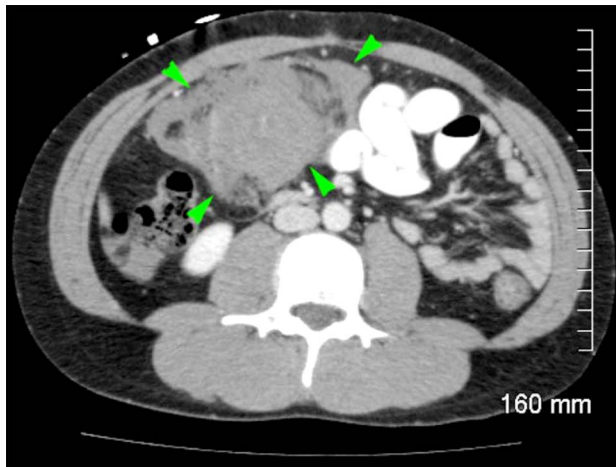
A patient with a history of Type-IV Ehlers-Danlos Syndrome developed severe abdominal pain secondary to vomiting, and an abdominal CT-scan to work-up the patient's symptoms revealed a large retroperitoneal hemorrhage. Green arrows identify the extent of the hemorrhage from the retroperitoneum into the mesentery on an axial slice of the abdomen by CT-scan.
